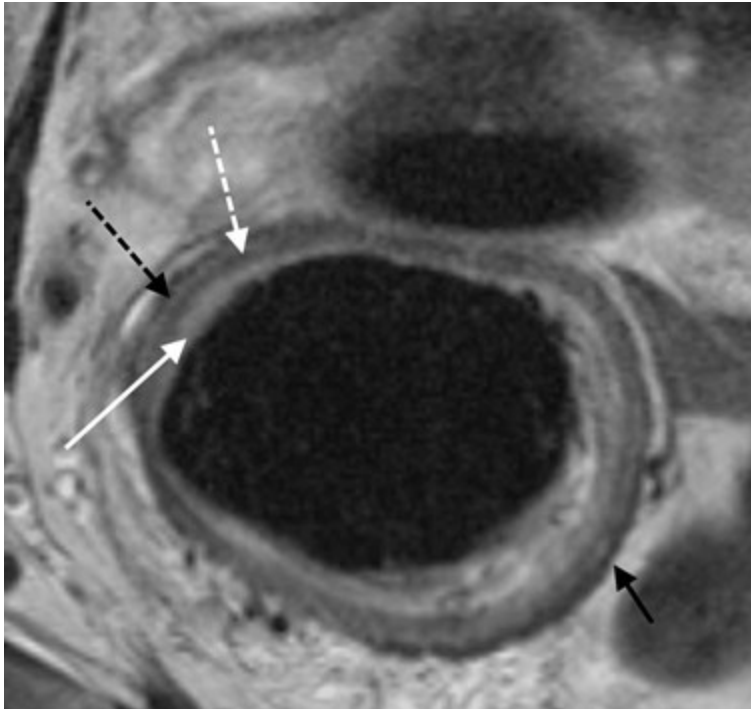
High-resolution axial T2-weighted MRI which shows the normal anatomy of the rectal wall.
